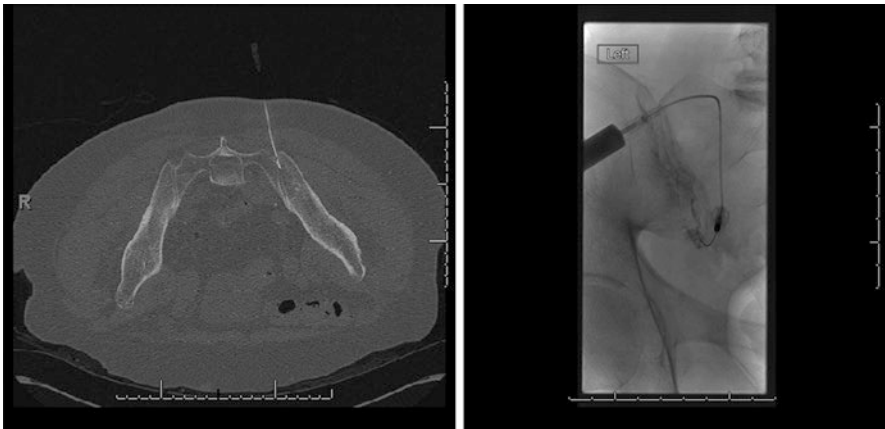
(Left) CT-guided diagnostic injection. (Right) Fluoroscopically guided SI injection with arthrogram outlining the joint
